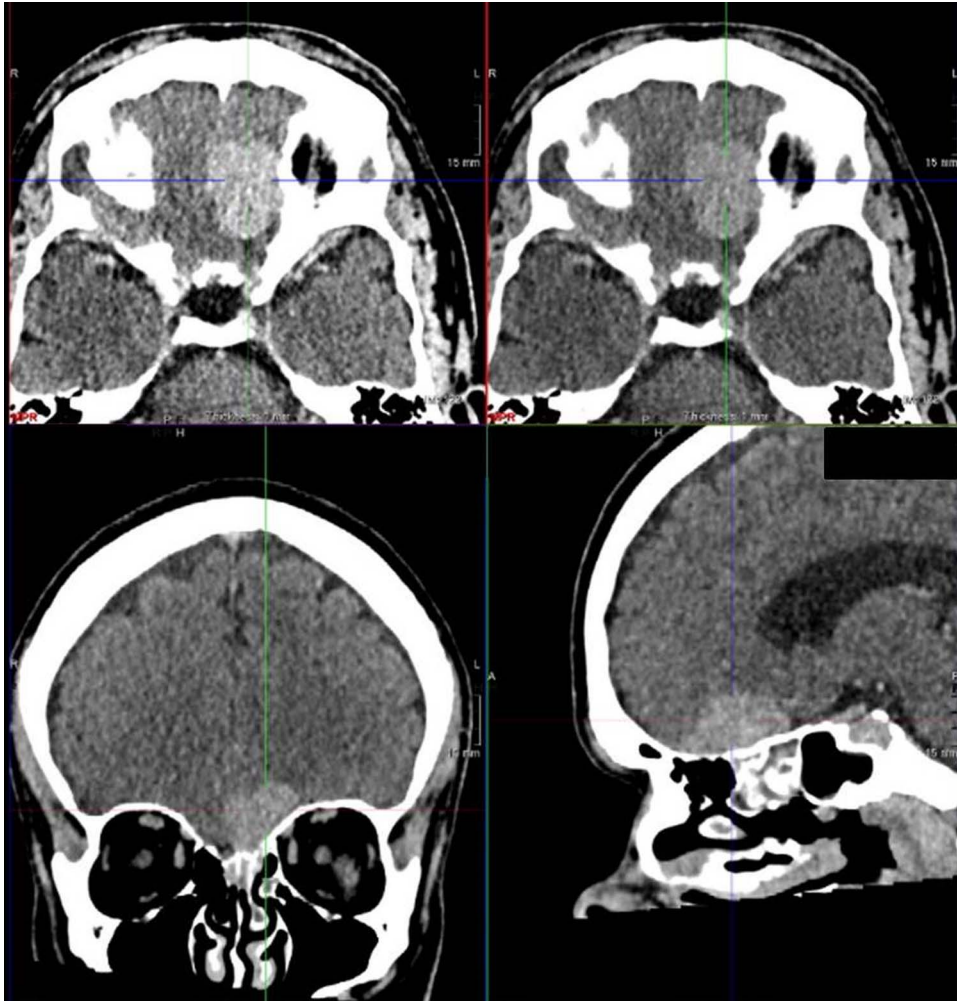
CT Head—Initial CT images showing a single enhancing and well-circumscribed lesion in the anterior cranial fossa floor.
